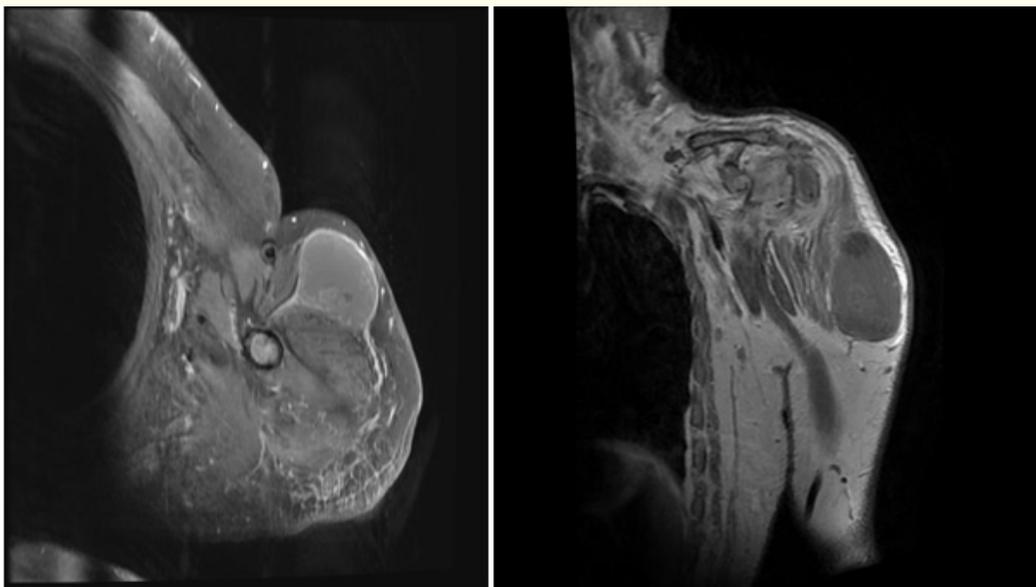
MRI images of shoulder.
